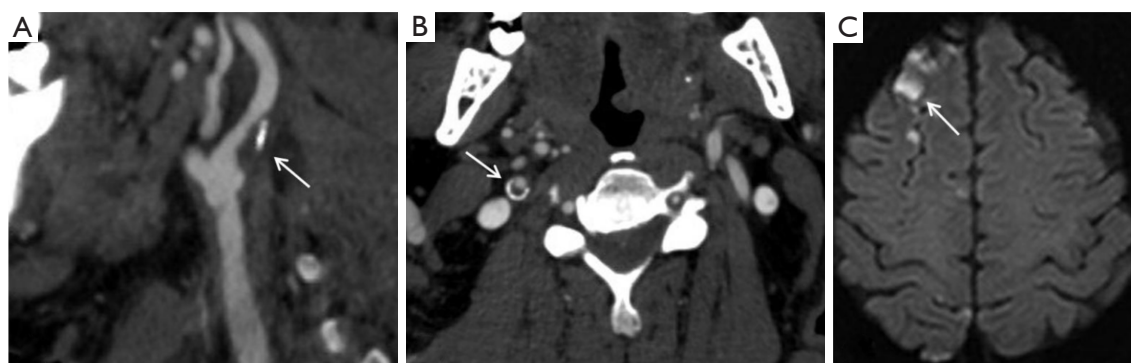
Images of a patient with acute ischemic stroke. CTA sagittal (A) and axial (B) show a plaque at the beginning of the right internal carotid artery (arrow), and MR DWI axial (C) shows acute cerebral infarction at the right frontal lobe. CTA, computed tomography angiography; MR, magnetic resonance; DWI, diffusion weighted imaging.
